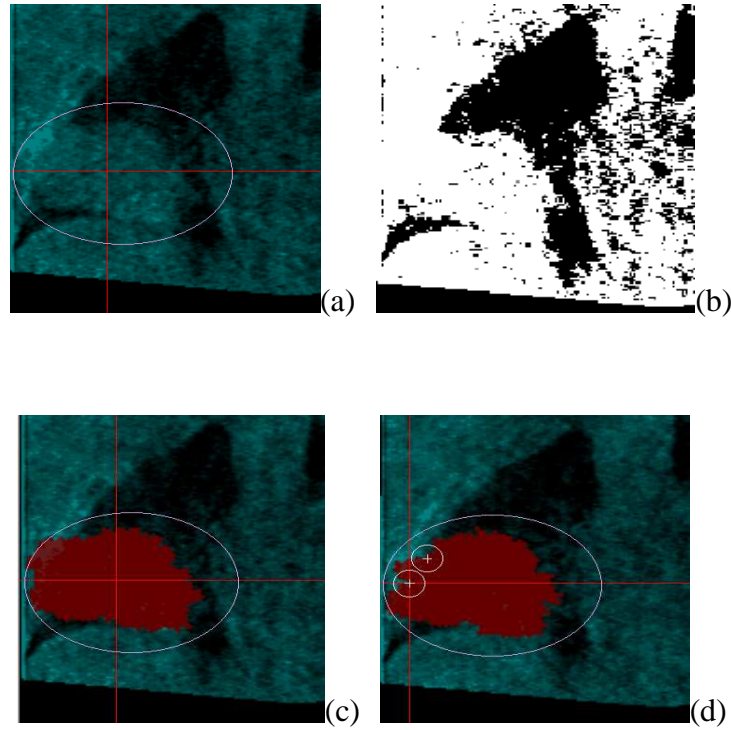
3D tumor segmentation in RC MVCBCT volumes based on the graph search method. The image is shown in a coronal plane. (a) original image; (b) result after Otsu threshold; (c) segmented result based on graph search (red region); (d) segmented result after user correction. The user added two constraint points in this image, which makes a change in the tumor surface.
